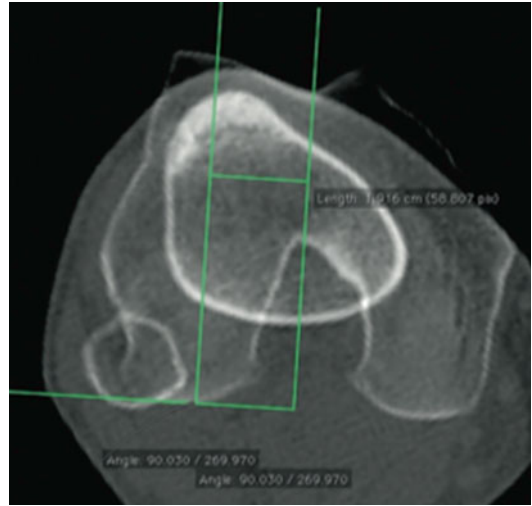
TT-TG measure performed on CT scan. The first cut is the reference cut that passes through the proximal trochlea at the level where the intercondylar notch has the shape of a roman arch. The second cut goes through the proximal part of anterior tibial tuberosity
